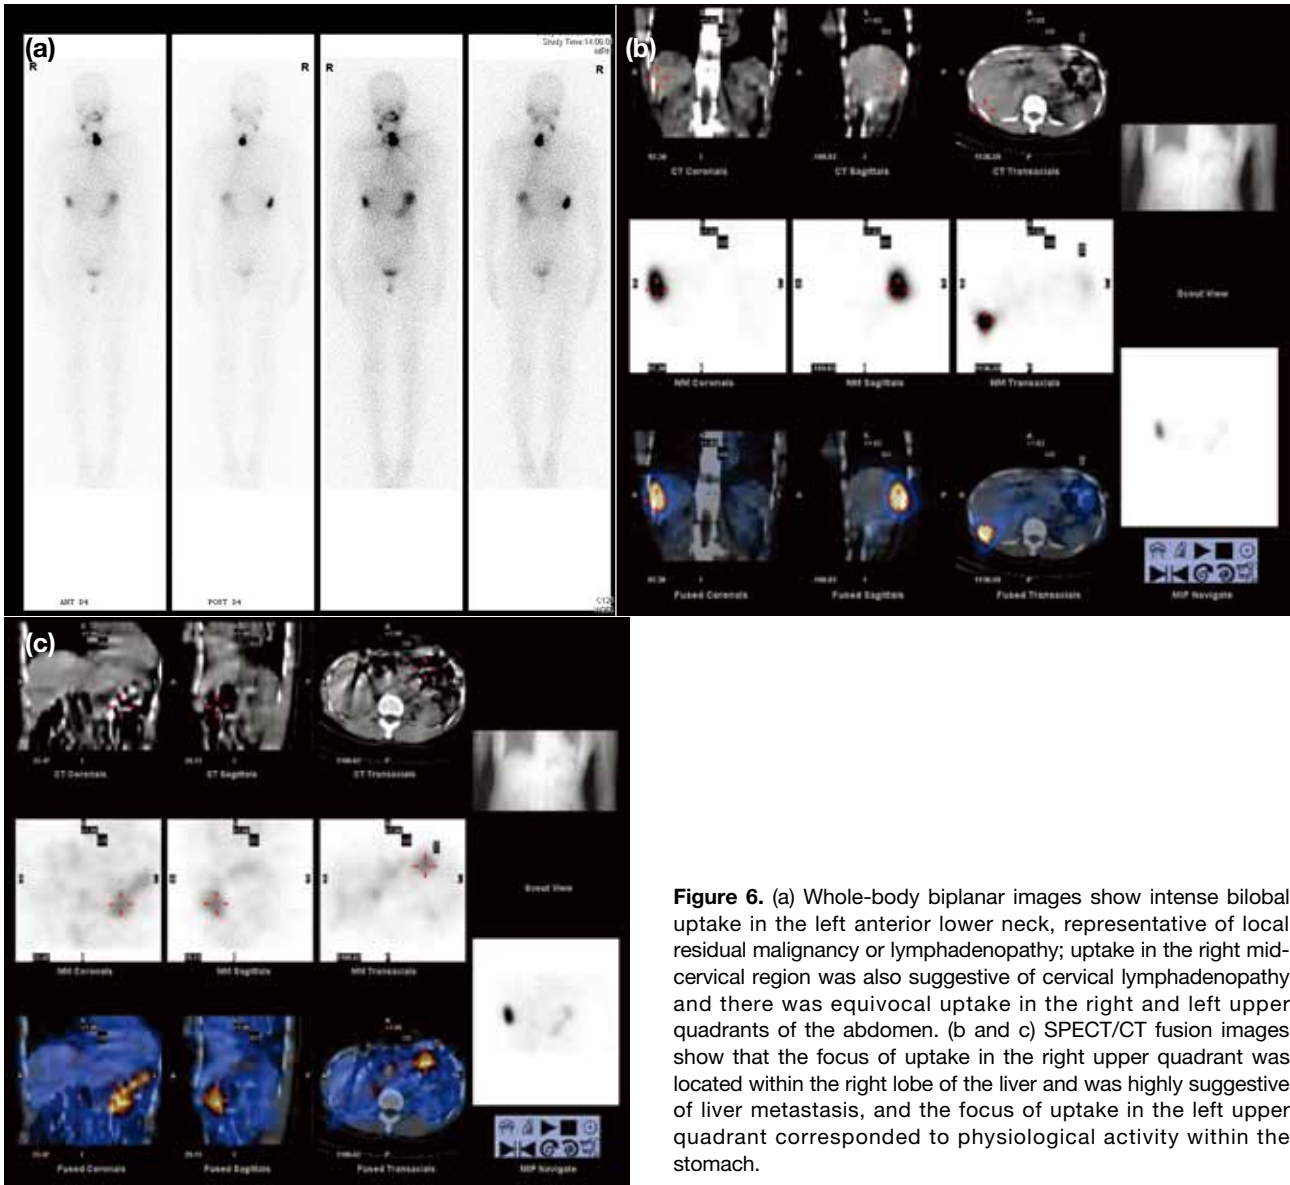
(a) Whole-body biplanar images show intense bilobal uptake in the left anterior lower neck, representative of local residual malignancy or lymphadenopathy; uptake in the right mid-cervical region was also suggestive of cervical lymphadenopathy and there was equivocal uptake in the right and left upper quadrants of the abdomen. (b and c) SPECT/CT fusion images show that the focus of uptake in the right upper quadrant was located within the right lobe of the liver and was highly suggestive of liver metastasis, and the focus of uptake in the left upper quadrant corresponded to physiological activity within the stomach.
